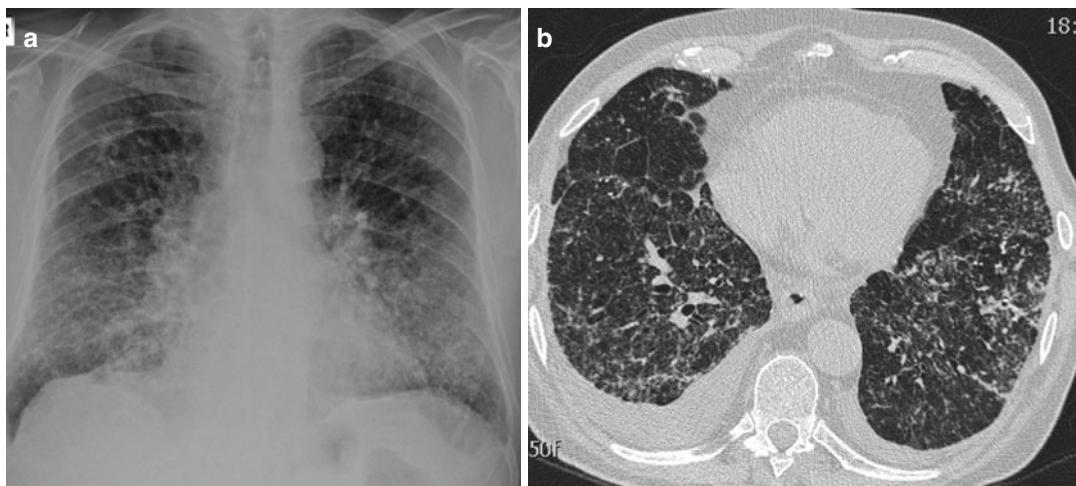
A 56-year-old patient with chronic lymphatic leukemia treated with *cyclophosphamide*, who developed widespread nodular densities and bilateral lymphadenopathy seen on a CXR (a). CT shows fine nodular pattern –
